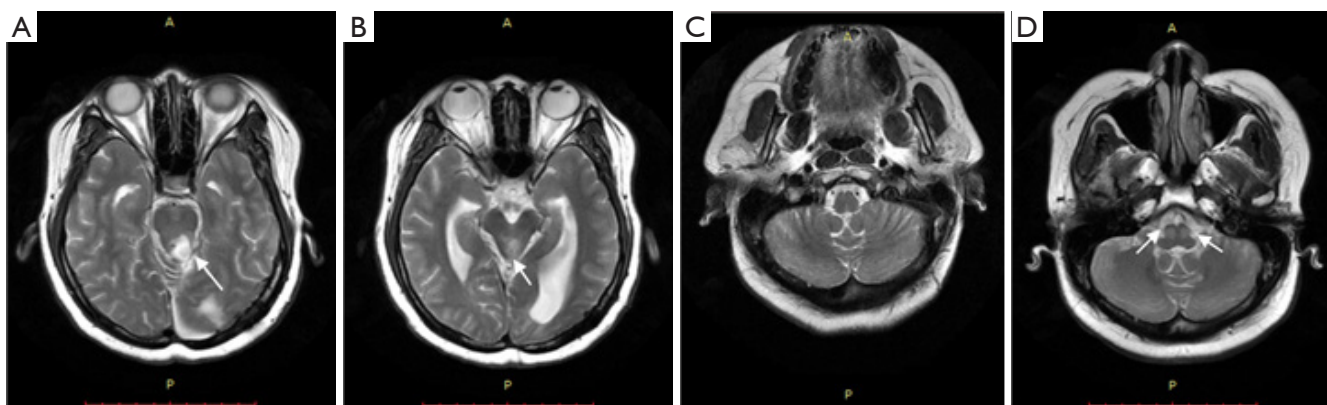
Imaging data of case 1. (A) MRI scan from January 26, 2018, showing multiple cavernous malformations (arrows) in the pons and cerebellum. (B) MRI scan from July 30, 2020, showing multiple cavernous malformations (arrows) in the pons and cerebellum. (C) MRI scan from January 26, 2018, showing no abnormalities in the ION. (D) MRI scan from July 30, 2020, showing a slight enlargement (arrows) of both sides of the ION with hyperintense T2 signals. MRI, magnetic resonance imaging; ION, inferior olivary nucleus.
